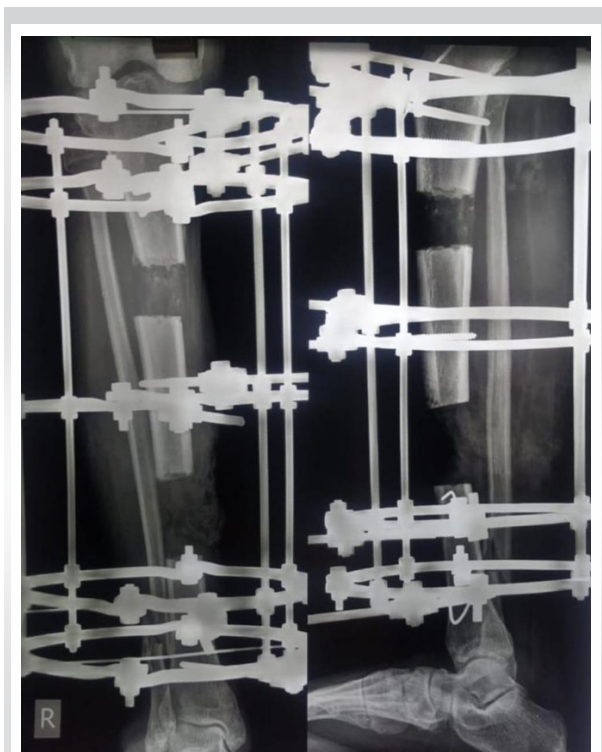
Immediate post-operative X-ray of right leg taken in anteroposterior and lateral view shows corticotomy levels and Ilizarov fixation.
